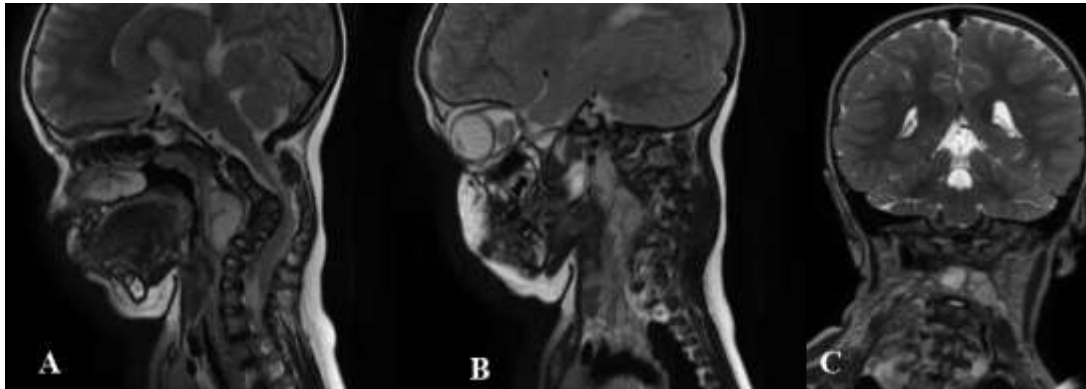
Boundary lesion between cervical and thoracic vertebrae in a 2 years old patient with NF1. MRI sagittal T2w - paramedian right (A) and left (B) - and coronal T2w (C). Pathologic tissue in prevertebral and paravertebral spaces, extending from C2 to D3, with plexiform features on the right side, where it involves deep and superficial muscular structures. This lesion extends in the right neural foramina between C3-C4 and C4- C5, and posteriorly in the epidural tract between C3, C4 and C5.
